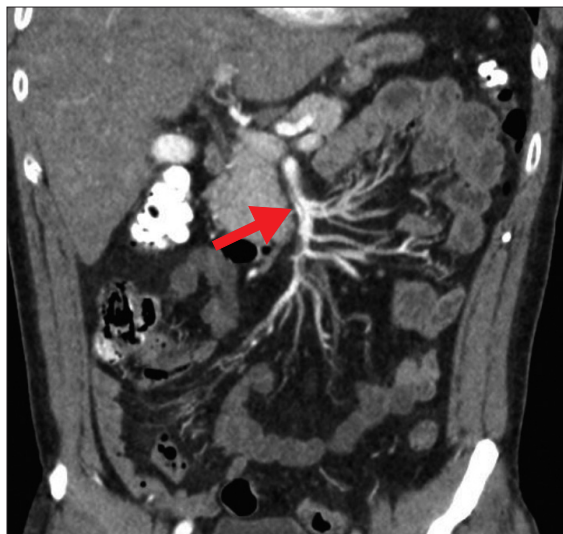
Presentation to the emergency department: abdominal computed tomography scan showing dissection of the superior mesenteric artery commencing just beyond the origin to the level of L2/L3, with opacification of false lumen (arrow).
